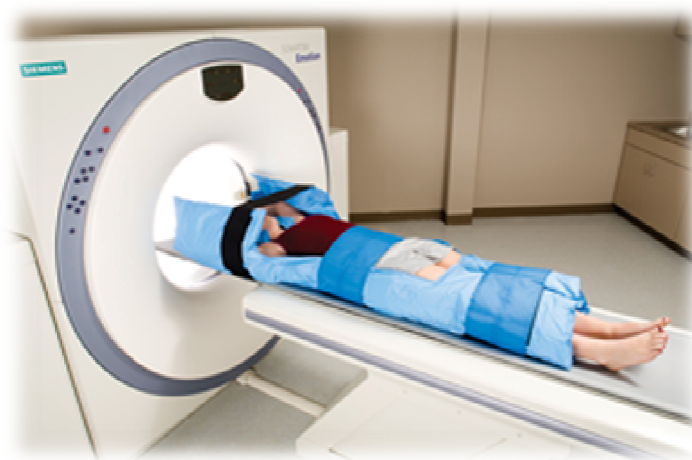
Patient immobilized with a Vac-Lok, ready to start a planning CT scan. It is visible that the immobilized patient barely fits through the opening (45).
